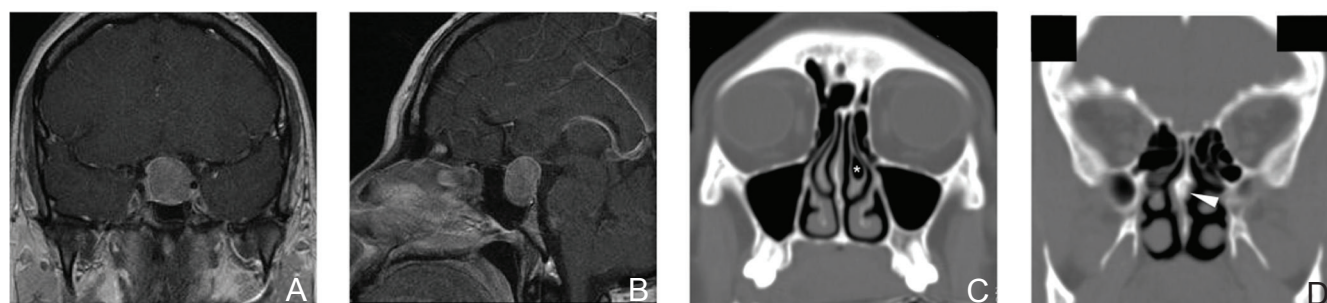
Case 1. Preoperative coronal (A) and sagittal (B) magnetic resonance images after administration of contrast medium show a homogeneously enhanced macroadenoma. Preoperative coronal computed tomography scans (C, D) show the concha bullosa of the left middle turbinate (*asterisk*) and deviation of the nasal septum to the right side (*arrowhead*).
